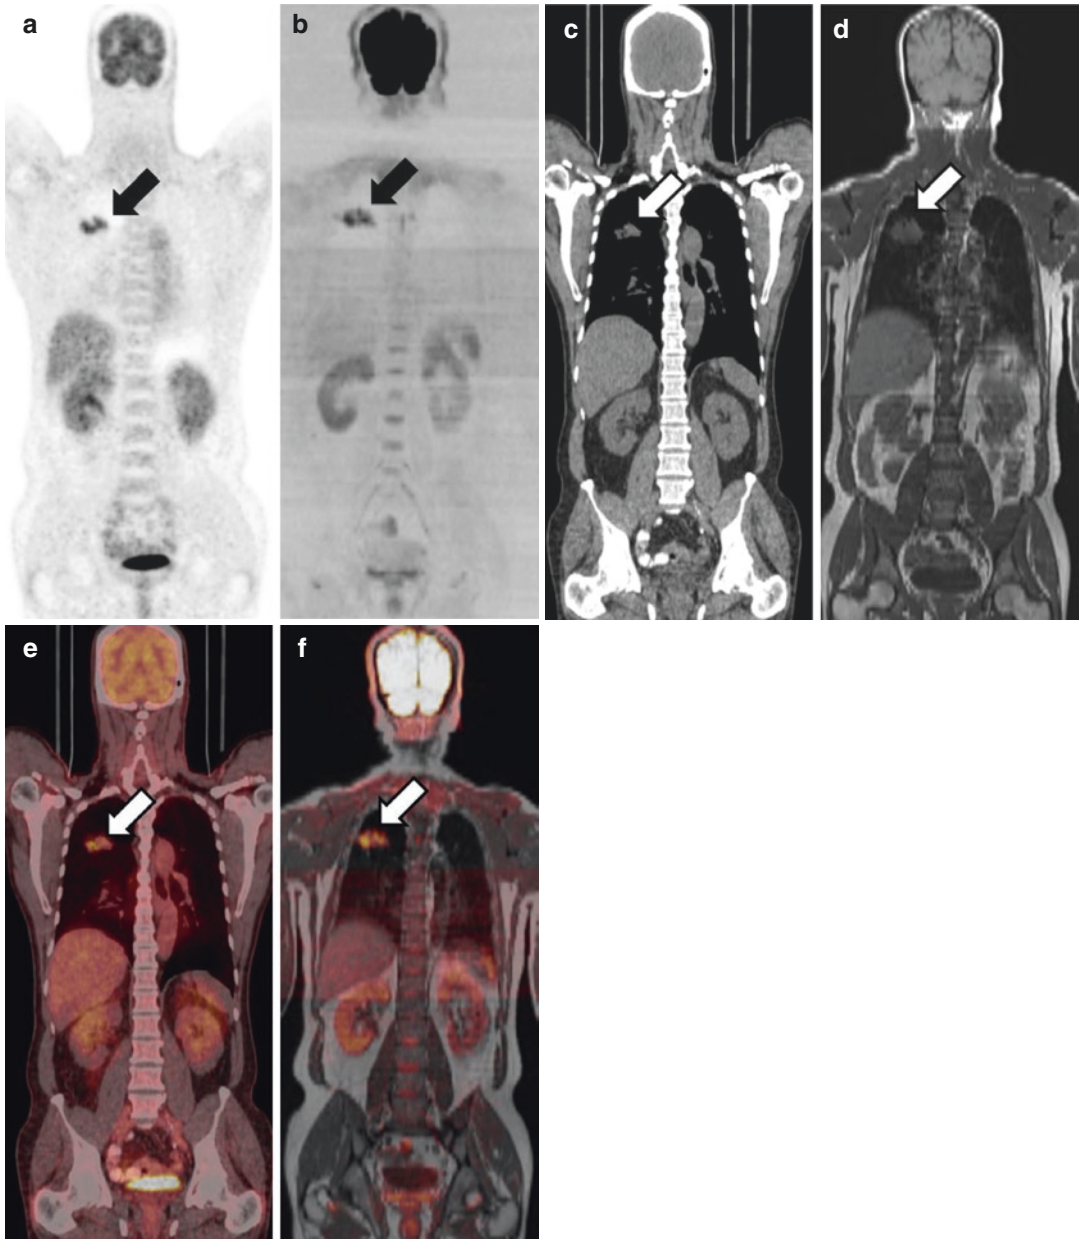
Side-by-side comparison of FDG-PET/CT (right) and whole-body MRI (left) in a patient with pulmonary squamous cell carcinoma stage T2a N0 M0 showing comparable image contrast of the tumor in the right upper lobe with both methods. (a) FDG-PET; (b)
